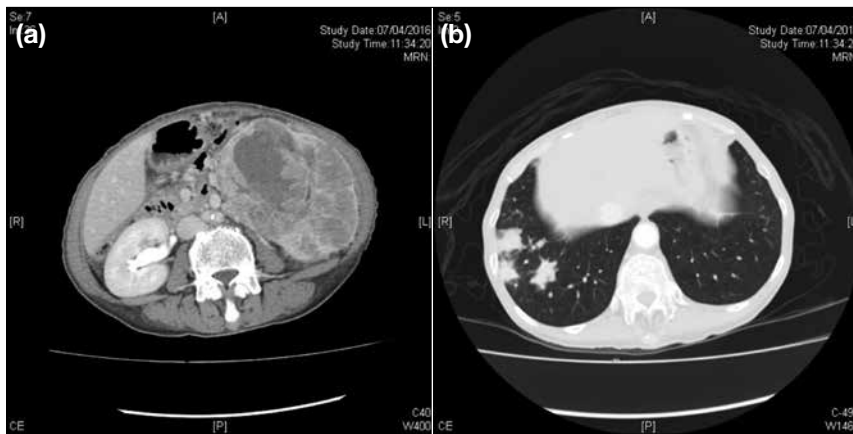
A 64-year-old woman with clear cell renal cell carcinoma. (a and b) Diagnostic contrast computed tomography images showing a 11.4-cm left renal mass with regional lymphadenopathy and lung metastases.
